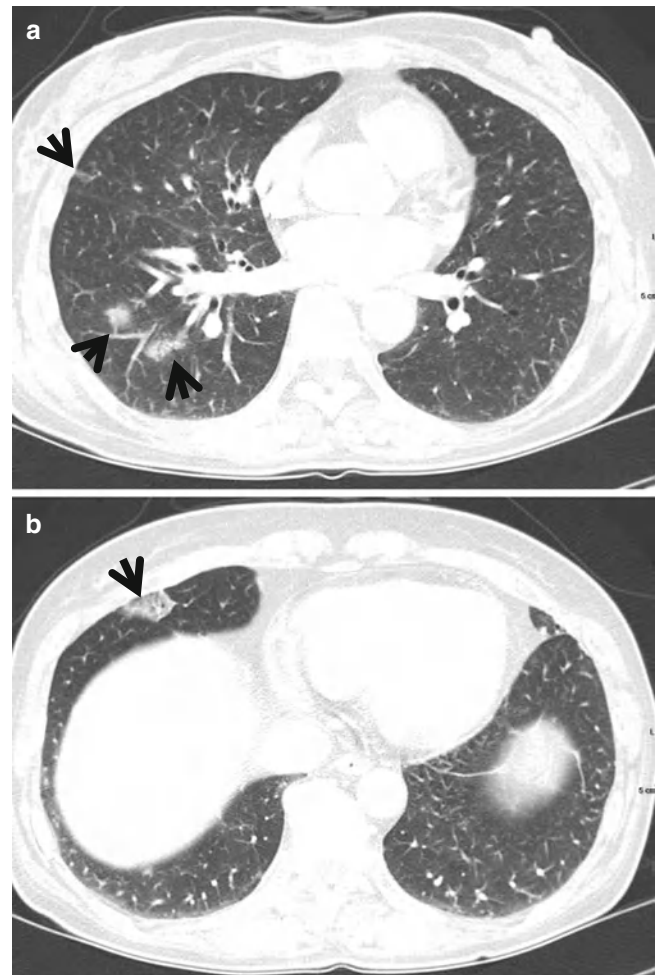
Iressa (gefitinib)-induced hypersensitivity pneumonia in a 53-year-old woman with lung adenocarcinoma and lung-to-lung metastases. (a, b) Lung window images of CT scans (5.0-mm section thickness) obtained at levels of inferior pulmonary veins (a) and liver dome (b), respectively, show patchy areas of parenchymal ground-glass opacity (*arrows*) in both lungs. The lesions disappeared spontaneously without any treatment
